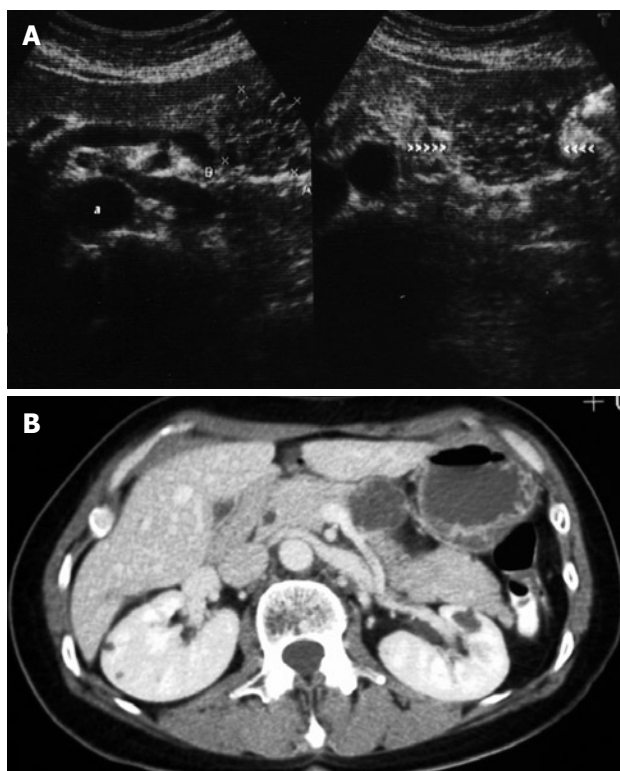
A well-circumscribed 35 mm polycystic lesion in the body of the pancreas, with thin septa within the lesion. A: US scan demonstrating the polycystic tumour of the body of the pancreas; B: CT scan showing the cystic tumour with fine septa.
